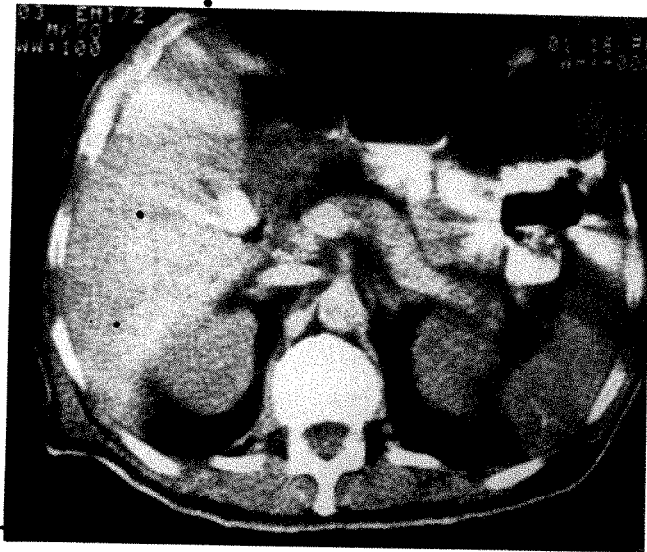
CT scan of 61-year-old man with suspected carcinoma of tail of pancreas. Horizontally oriented pancreas is seen in its entirety and is of normal size and configuration.
